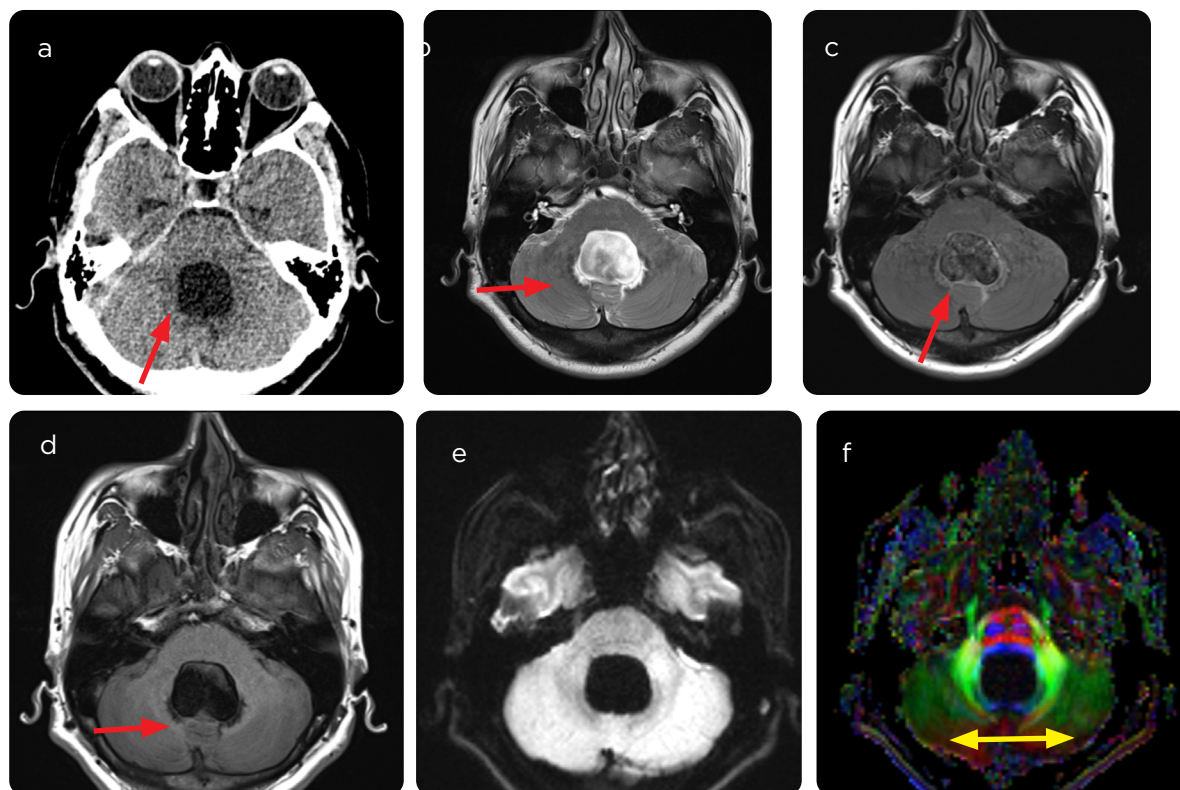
Cysticercus in colloidal vesicular stage occupying the IV ventricle. a) Axial CT scan: CSF-like lesion. b) spin-echo MRI and FLAIR with T2 information: heterogeneous lesion with higher signal and with little perilesional edema. c) Sequence with T1 information: CSF-like signal. d) Diffusion sequence without restriction to diffusion and f) color map tractography: displacement of the white matter tracts adjacent to the cysticercus.
